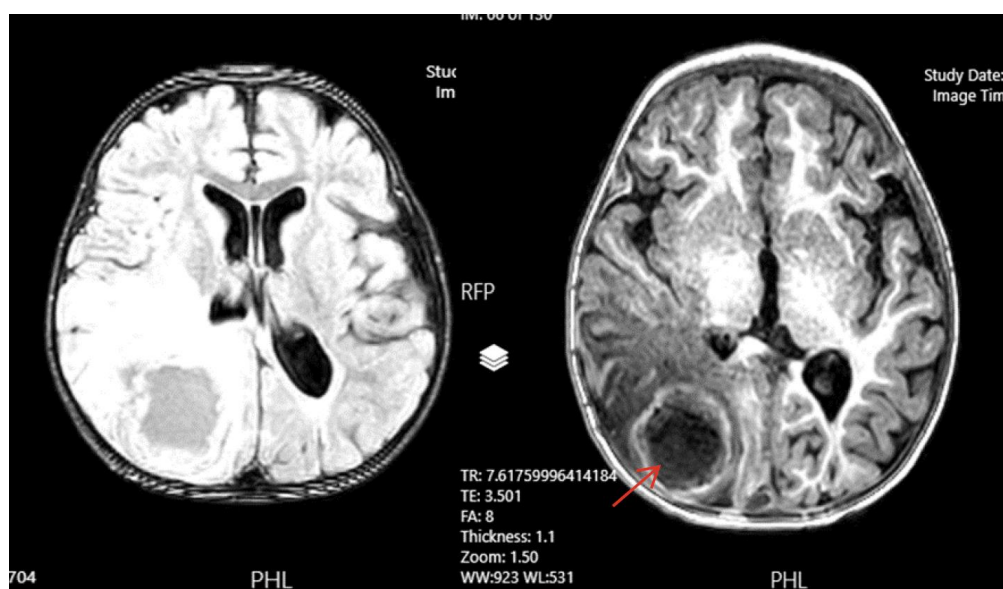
Brain MRI (post-second burr hole drainage, day 7) showing persistent multiloculated abscess with reduced size (arrow).
